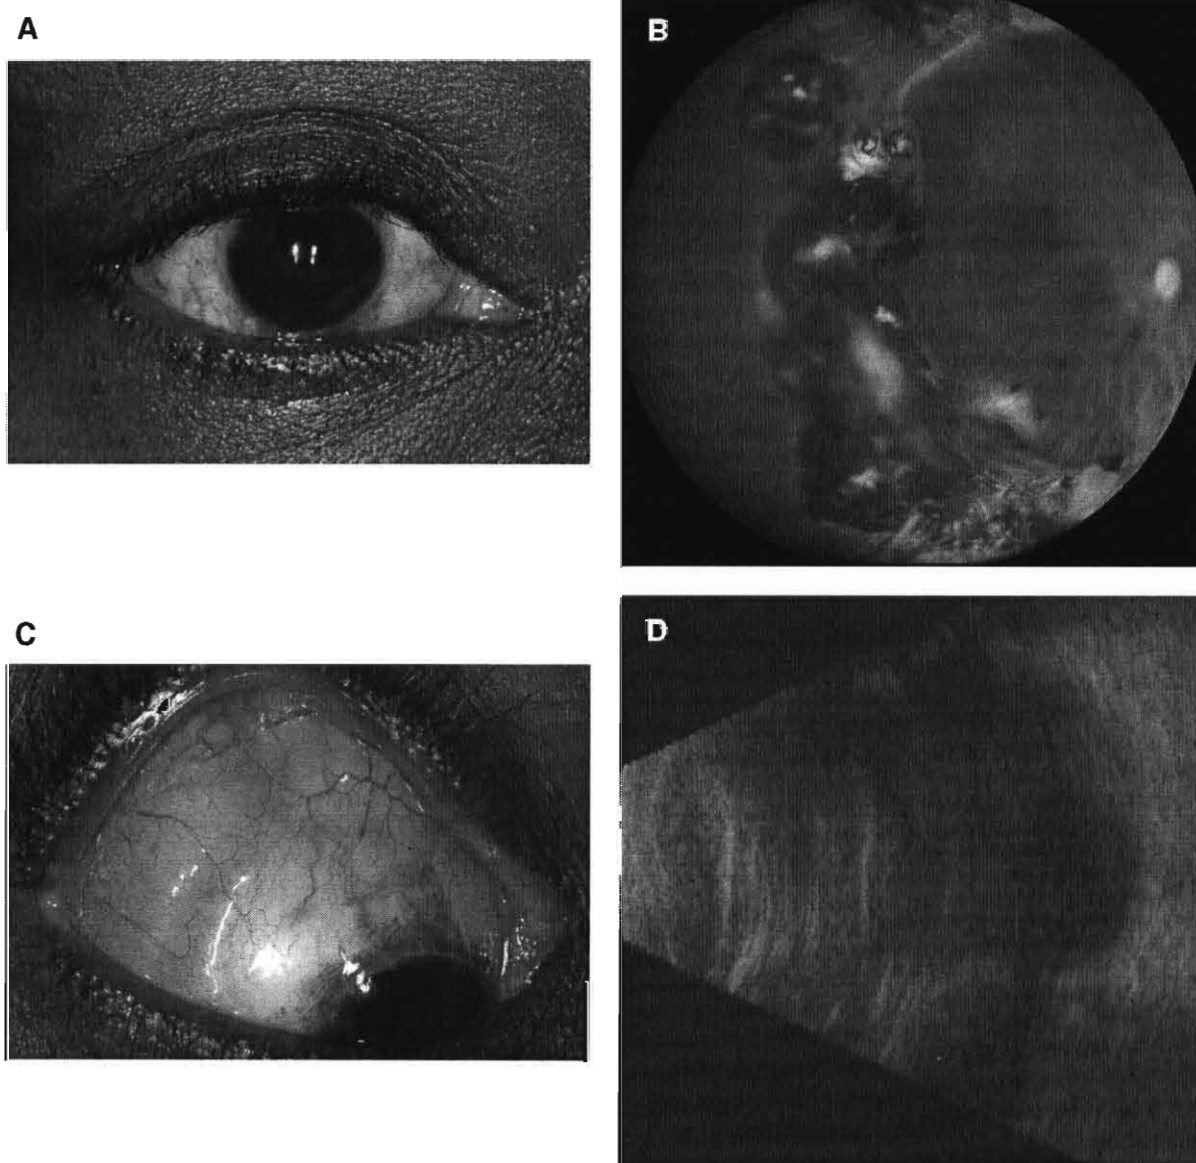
Case 3. A 46-year-old man had an orbital mass that proved to be a swollen MIRAgel scleral buckle used for retinal detachment repair 12 years earlier. A, Patient noted a palpable mass through the eyelid temporally. B, Panoramic image shows chorioretinal scars and high scleral buckling effect 12 years after retinal detachment surgery. C, Mass was found to be translucent, with overlying prominent conjunctival vessels. Like a circumferential scleral buckle, the large mass appeared to encircle the eye. D, Ultrasonography confirmed 6 mm of ocular indentation by echolucent mass with orbital shadowing. This was twice the thickness of the nasal portion of the scleral buckle. Observation was advised.
